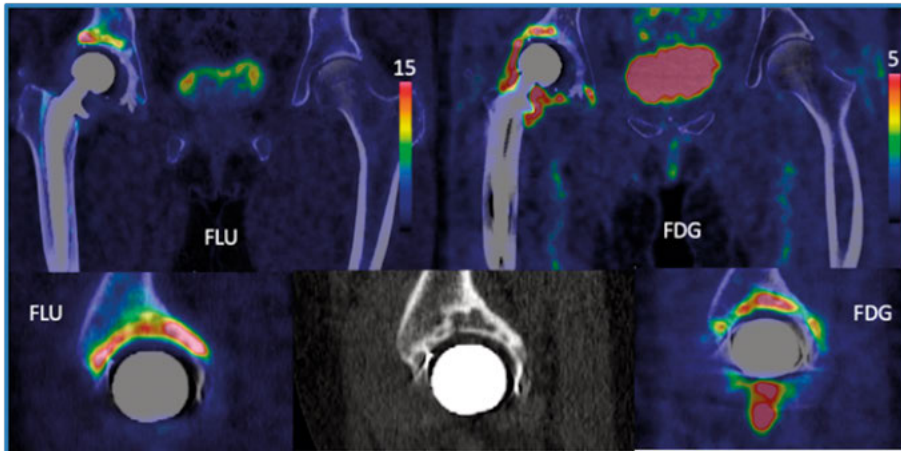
Comparative 18F-fluoride and 18F-FDG PET/CT imaging in suspected isolated acetabular infection (Study IV). The left panel (FLU: 18F-fluoride PET/CT) demonstrates increased periprosthetic tracer uptake around the acetabular component, reflecting elevated bone turnover (SUVmax 26.9). The right panel (FDG: 18F-FDG PET/CT) shows moderate metabolic activity at the same location (SUVmax 7.5). The case represents a 58-year-old patient with a prosthesis in situ for 13 years and in retrospect suspected isolated cup infection; however, EBJIS classification was negative (infection unlikely). At revision surgery the acetabular component was found to be loose, but unfortunately no intraoperative cultures were obtained from this region.
